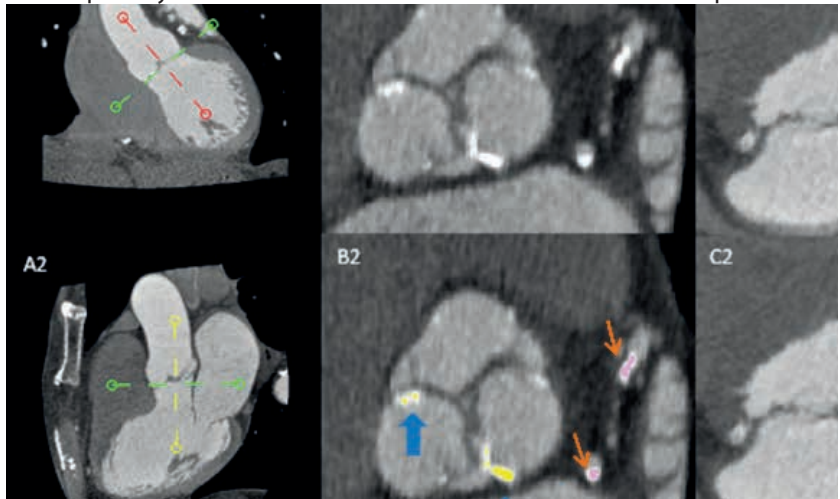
Aortic and mitral valve calcium assessed on contrast cardiac computed tomography angiography with the threshold of ≥ 800 HU. By adjusting the 3 orthogonal multi-planar reformation planes (red, yellow and green dotted lines), based on aortic valve orientation, in the coronal (A1) and single oblique sagittal (A2) views, the double oblique transverse view depicting the real aortic valve short axis (B1) was created. By using the sequential axial images below the aortic annulus, the mitral valve could also be visualized in this view (C1). B2 demonstrates the calcium detected on the aortic valve. Blue arrows point the aortic valve calcium colored yellow after selecting it. Orange arrows point the coronary artery calcium colored pink (not selected). C2 demonstrates the calcium detected on the mitral valve. Red arrow points mitral valve calcium colored green after selecting it.
